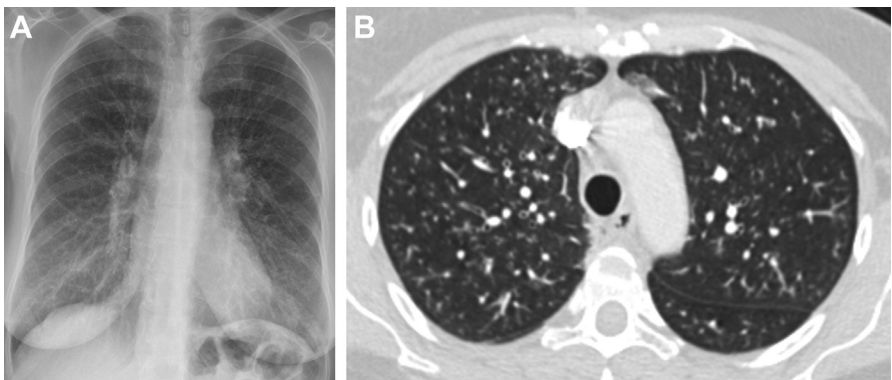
Fifty-nine-year-old woman with productive cough and positive rhinovirus PCR. (A) Frontal chest radiograph shows subtle bilateral micronodules throughout both lungs. (B) Axial chest CT confirms bilateral 2-3 mm centrilobular tree-in-bud nodules in the upper lobes.
